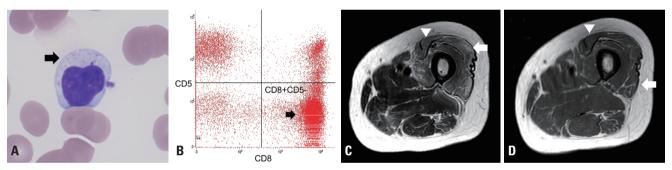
Peripheral blood smear, flow cytometry, and thigh magnetic resonance imaging findings. (A) Blood smears show large granular lymphocytes (LGL) with eccentric nuclei and large cytotoxic granules (arrow, ×200). (B) Flow cytometry with large CD8+ expansions of T-LGLs with CD5- expression (arrow). (C, D) Thigh magnetic resonance image revealed T2 high signal intensity (C, T2-weighed image) and mild fatty infiltration (D, T1-weighed image) of the vastus lateralis (arrow) with relatively preserved rectus femoris (arrowhead).
